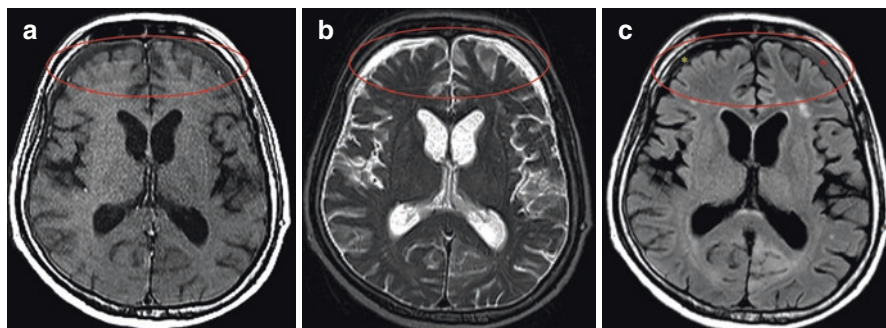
Bifrontal extra-axial collections are observed in MR images of a 67-year-old male patient. The collections are hypointense on T1 (a) and hyperintense on T2 (b), but the collection density is higher on T1 than CSF on the left side. On FLAIR sequence (c), the collection signal on the right is suppressed (subdural hygroma), while the left collection is not suppressed due to its hemorrhagic content (chronic subdural hematoma)
